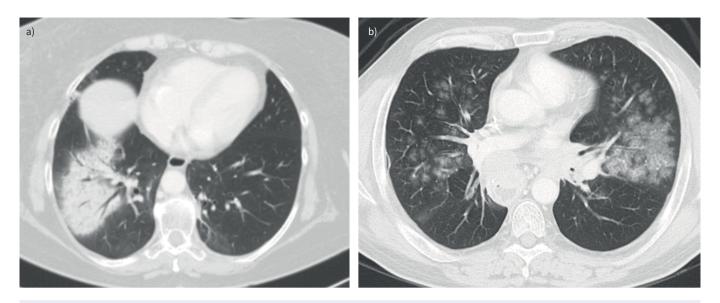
Trastuzumab-induced interstitial lung disease in a patient with breast cancer. a) Computed tomography (CT) scan shows airspace consolidation in the right lower lobe. b) FOLFIRI (folinic acid, fluorouracil, irinotecan)-induced acute alveolar haemorrhage in a 52-year-old man with oesophageal cancer. Bilateral ground-glass opacities on high-resolution CT are due to subtotal alveolar filling with blood. Alveolar haemorrhage resolved rapidly following glucocorticoid treatment, but the patient died due to metastatic disease.
